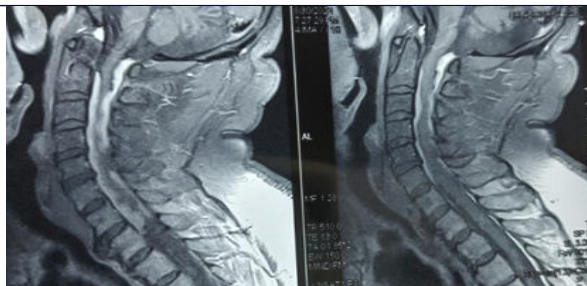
Pre-operative MRI images showing T1 contrast enhancing cervical intradural lesion with cord compression.
